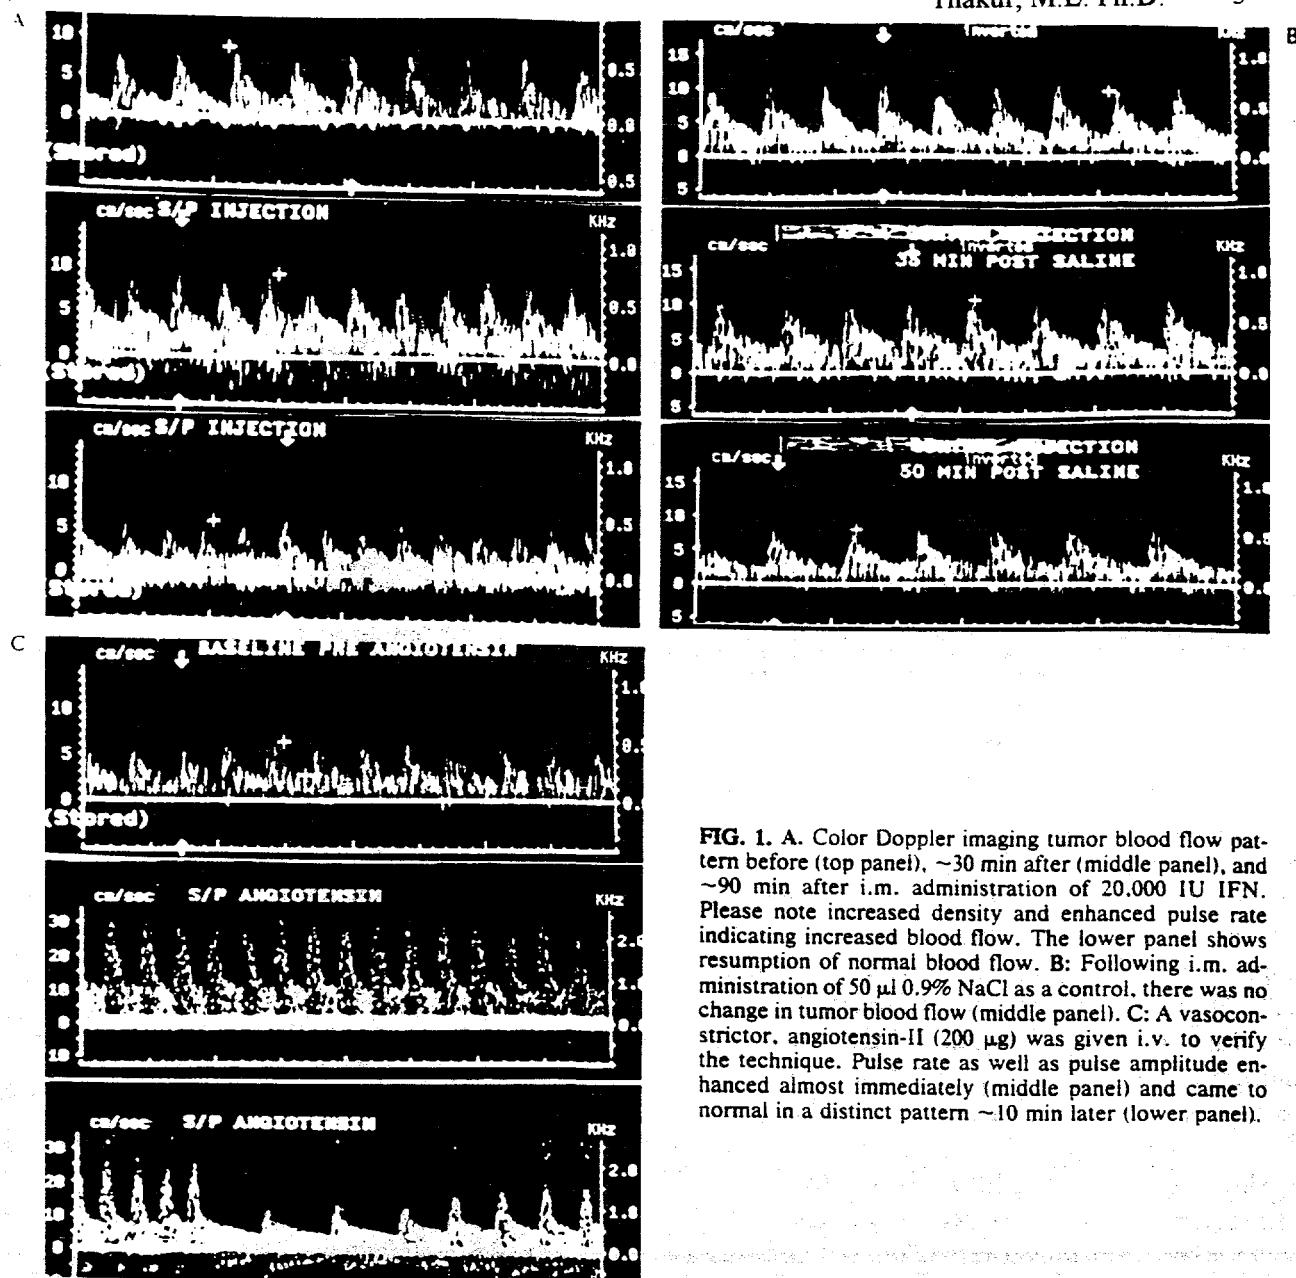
A. Color Doppler imaging tumor blood flow pattern before (top panel), ~30 min after (middle panel), and ~90 min after i.m. administration of 20,000 IU IFN. Please note increased density and enhanced pulse rate indicating increased blood flow. The lower panel shows resumption of normal blood flow. B: Following i.m. administration of 50 μ l 0.9% NaCl as a control, there was no change in tumor blood flow (middle panel). C: A vasoconstrictor, angiotensin-II (200 μ g) was given i.v. to verify the technique. Pulse rate as well as pulse amplitude enhanced almost immediately (middle panel) and came to normal in a distinct pattern ~10 min later (lower panel).
